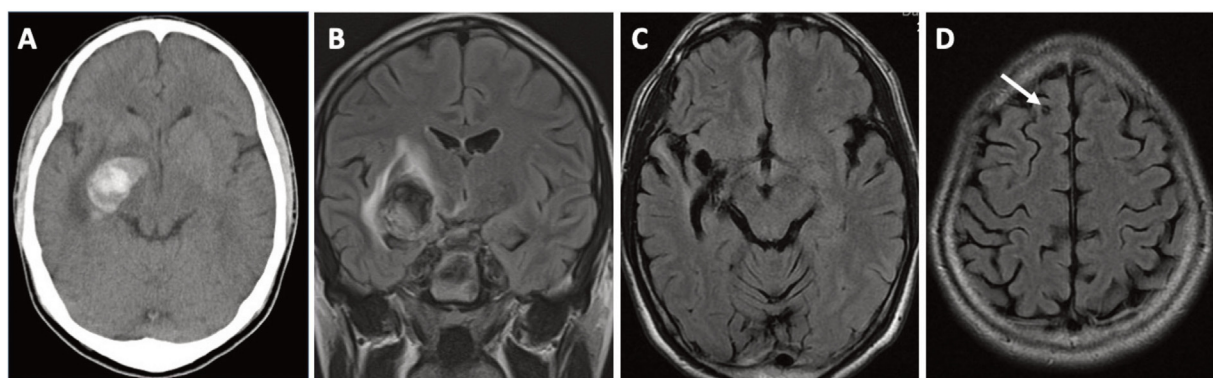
Case 1. Axial plain CT scan (A) and coronal MRI FLAIR (B) images show a cavernoma in the right temporal stem. Postoperative follow up MRI FLAIR images show removal of the right temporal cavernoma (C) and the remaining small right frontal cavernoma (D, arrow).
